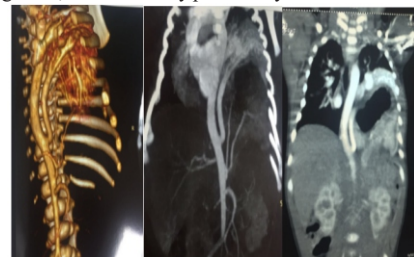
CT angiogram showing the lung sequestration
